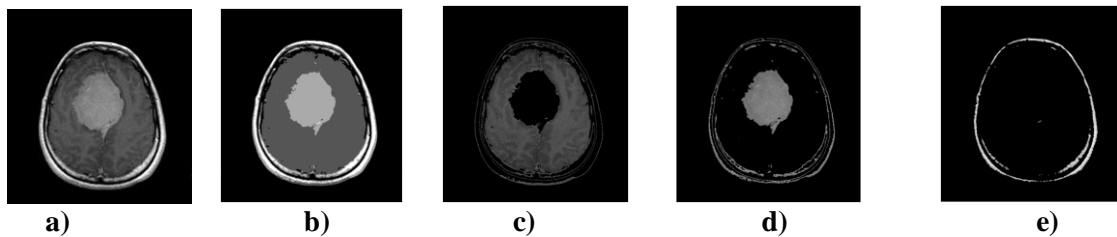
7 k-means algorithm applied on MRI slice (3 classes in this case)
